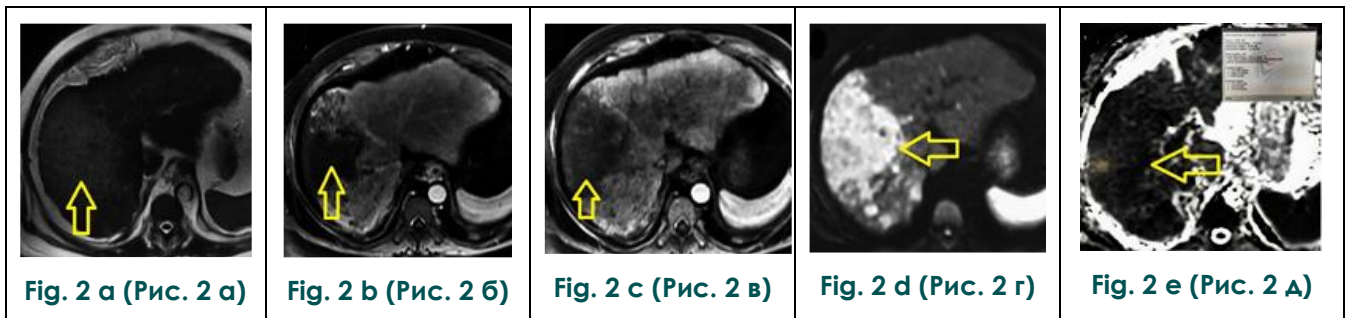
MRI of 65-years-old man with hepatocellular carcinoma.
